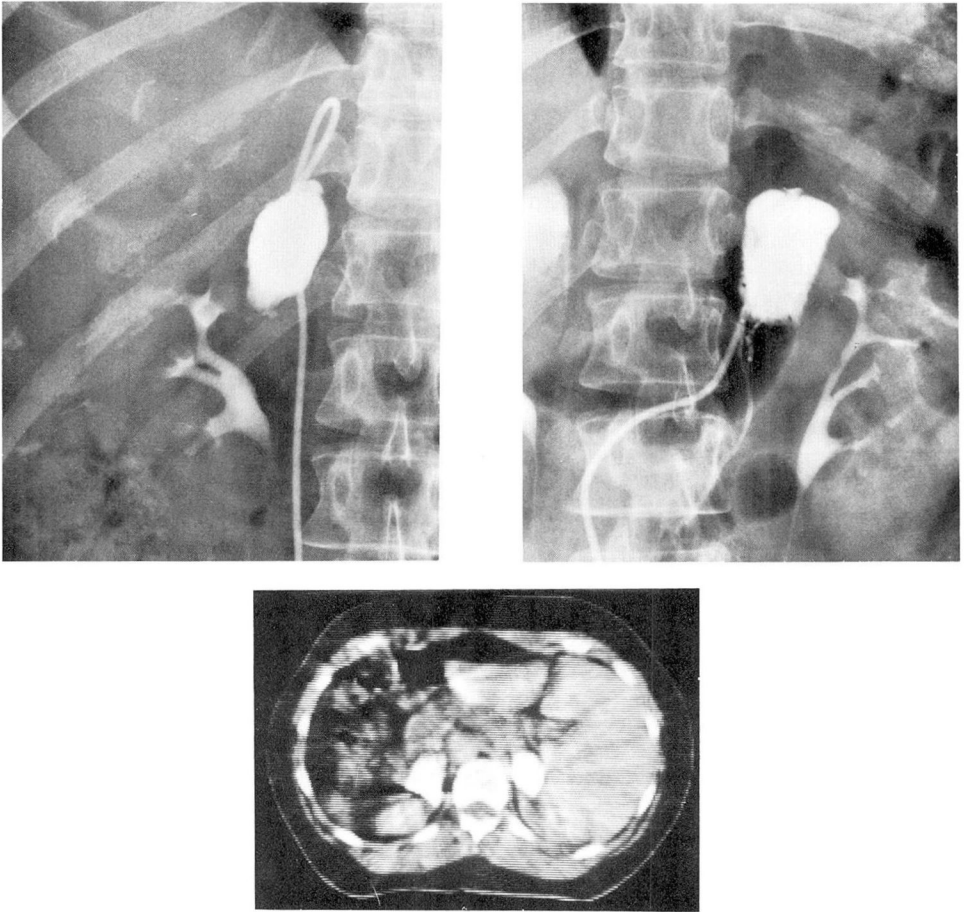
A, Roentgenogram showing successful rupture of the right adrenal gland. B, Roentgenogram showing successful rupture of the left adrenal gland. C, Computed tomography of the same patient demonstrating collections of contrast material within both adrenal glands.
